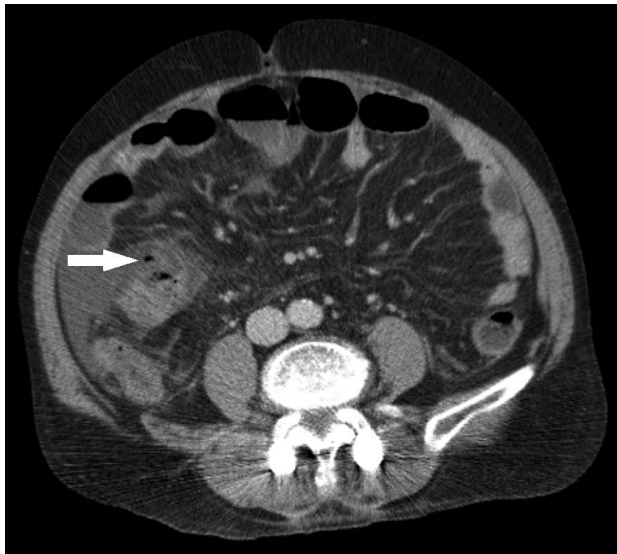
CT of case 1 indicates diffuse edematous wall thickening of the ascending colon and ileum, which is accompanied by diffuse mesentery haziness, fluid collection, fat infiltration, and free air (arrow).
